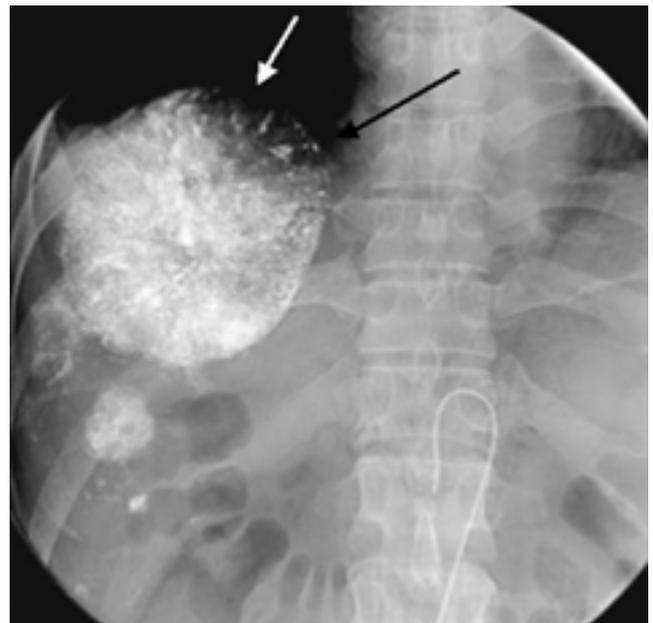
Plain radiograph obtained before TACE shows lipiodol washout area (arrows) in the superomedial aspect of the lipiodol uptaken tumor.
